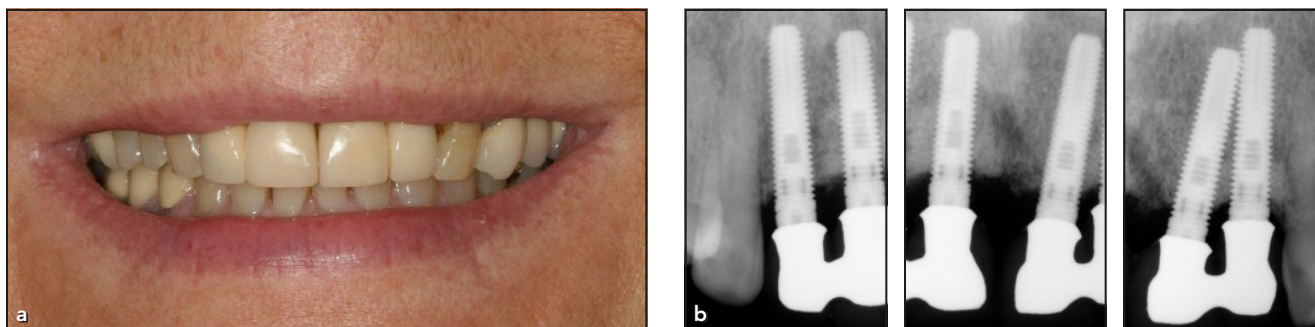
Outcome at 5-year recall. (a) Smile. (b) Radiographic appearance.
